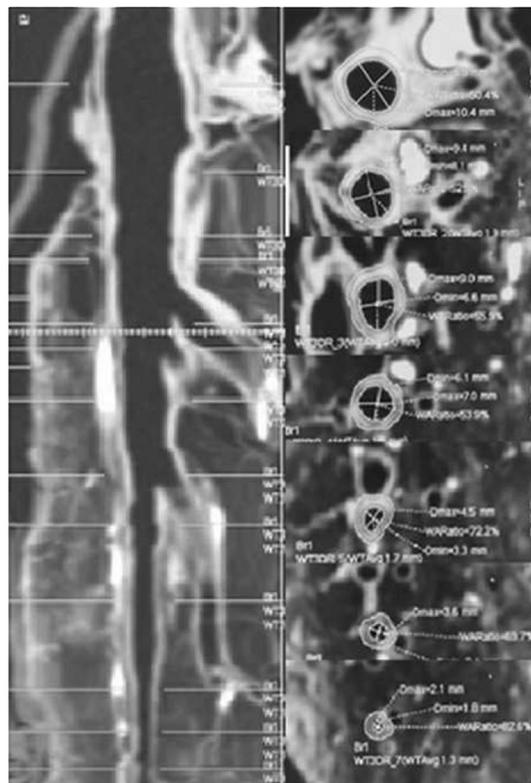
Images of the standard-dose scan and low-dose settings were reconstructed using eleven ASIR-V strength levels from 0 to 100% with 10% interval (hereafter, ASIR-V<sub>0–100</sub>). Images of CT scans were reconstructed using lung kernel (edge enhancement) for airway measurement [9, 28, 29], to facilitate precise segmentation and measurement by software.
